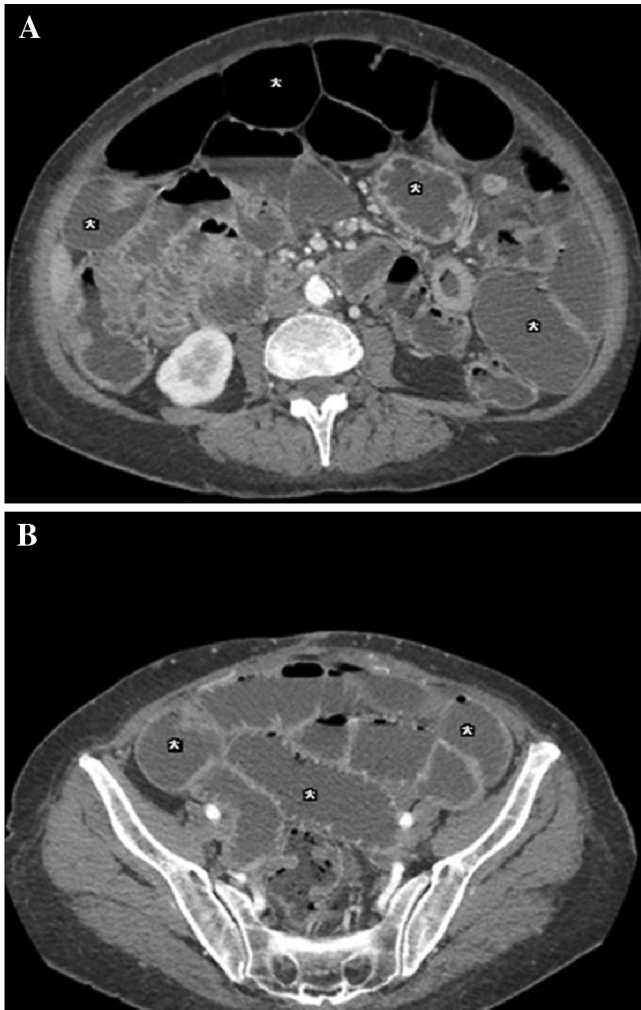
Diffusely dilated small bowel loops in a patient with scleroderma. A, B Axial contrast-enhanced CT images demonstrate diffusely dilated small bowel loops in both the upper and lower abdomen (*asterisks*) with no abrupt transition zone, thus excluding mechanical SBO.
